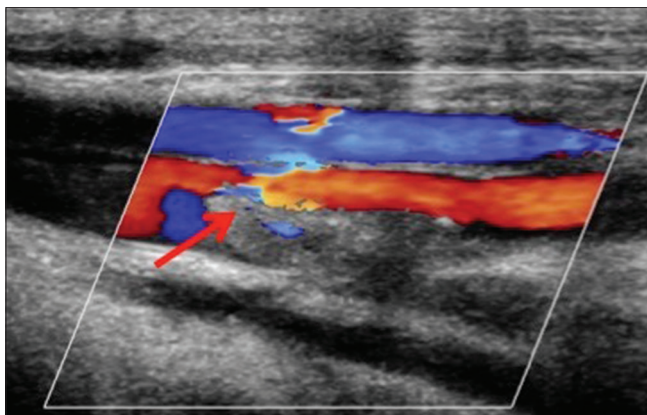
Doppler ultrasonography showing absence of color flow in the left common femoral vein suggestive of thrombosis
